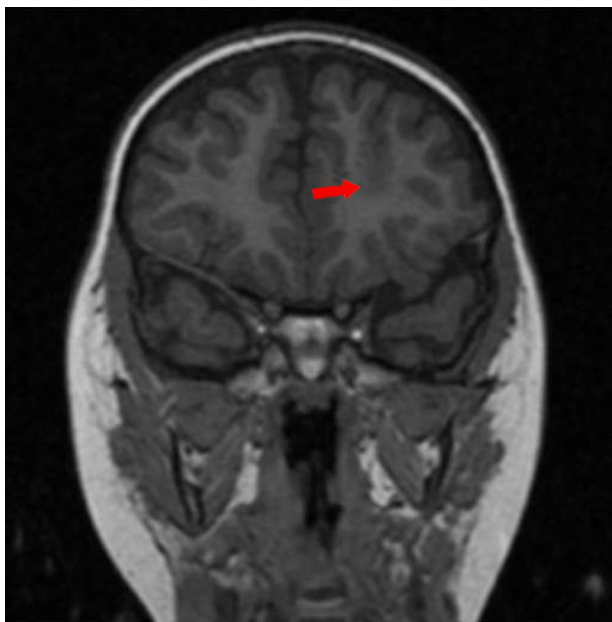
High-resolution (3-T) T1-weighted MRI scan (coronal section) revealing dysplasia at the bottom of the left superior frontal sulcus (loss of differentiation between grey and white matter).
